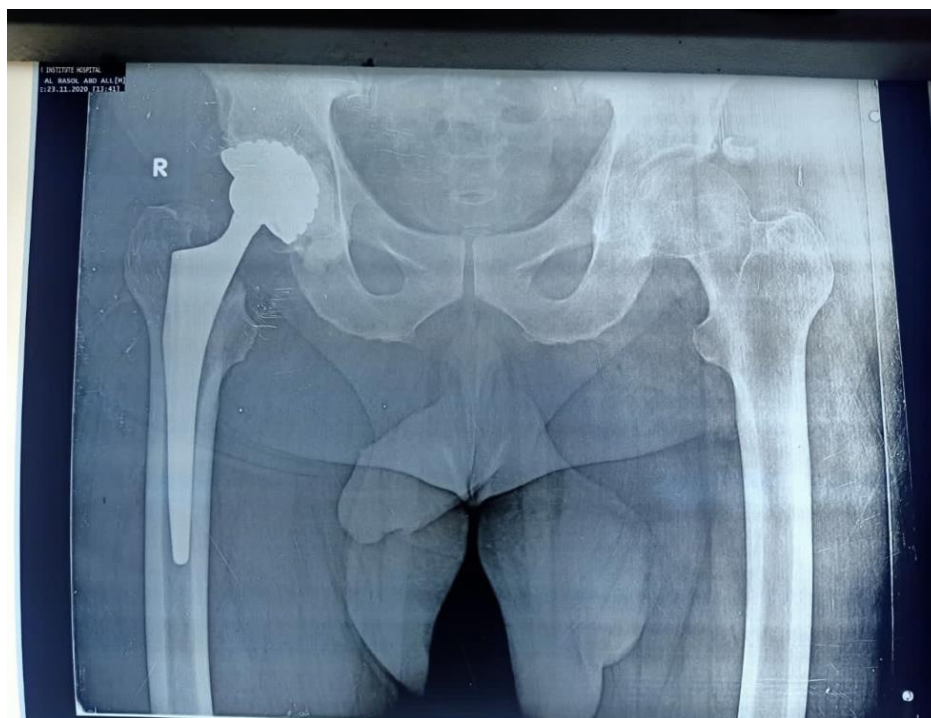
Post-operative radiographs of RT dual-mobility primary THA in a 70-year-old male.
